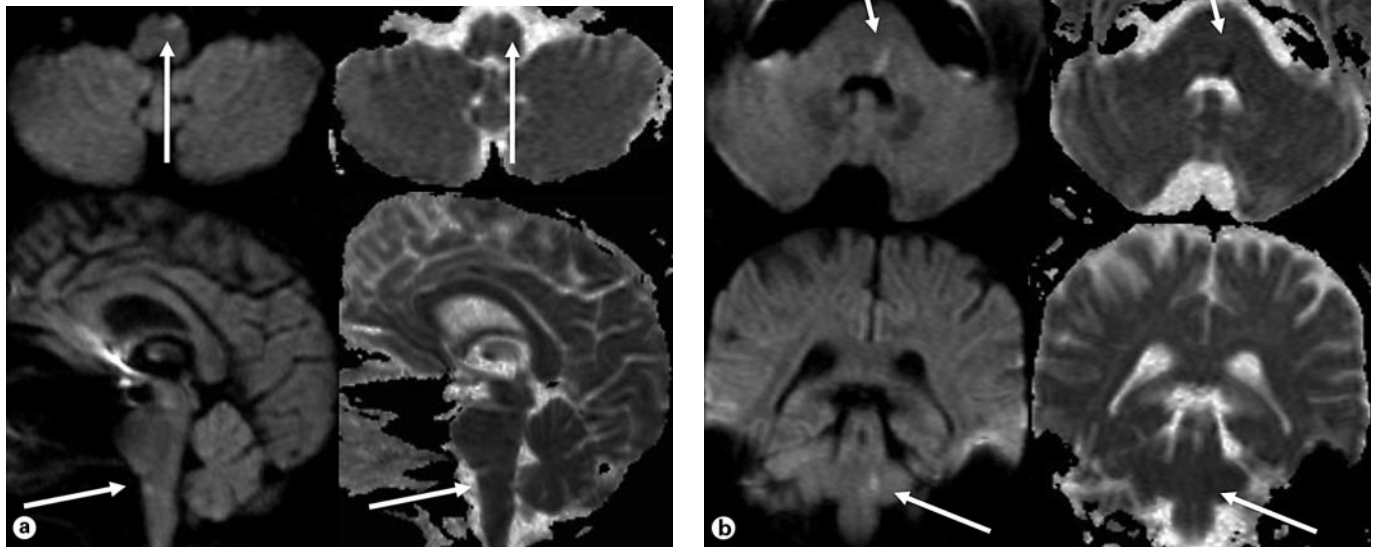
Exemplary DWI ($b = 1,000 \text{ s/mm}^2$ and ADC) of 2 patients performed within 6 h after symptom onset presented with patient's number, time latency and planes (clockwise from top left, arrows indicating ischemia). a Patient 3, 3.5 h (axial $b = 1,000$, axial ADC, sagittal ADC, sagittal $b = 1,000$). b Patient 5, 5.0 h (axial $b = 1,000$, axial ADC, coronal ADC, coronal $b = 1,000$).
